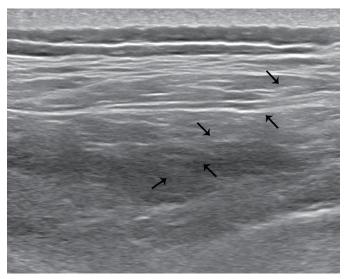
Ultrasound image of 52-year old females shows neddle (arrows) in the trigger point
